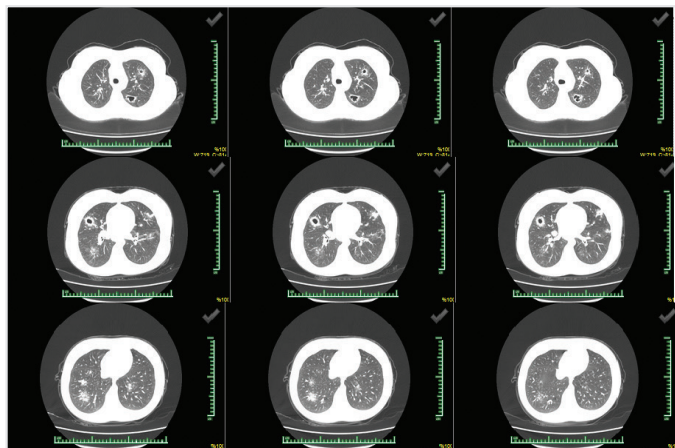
Thorax computed tomography images of the patient
